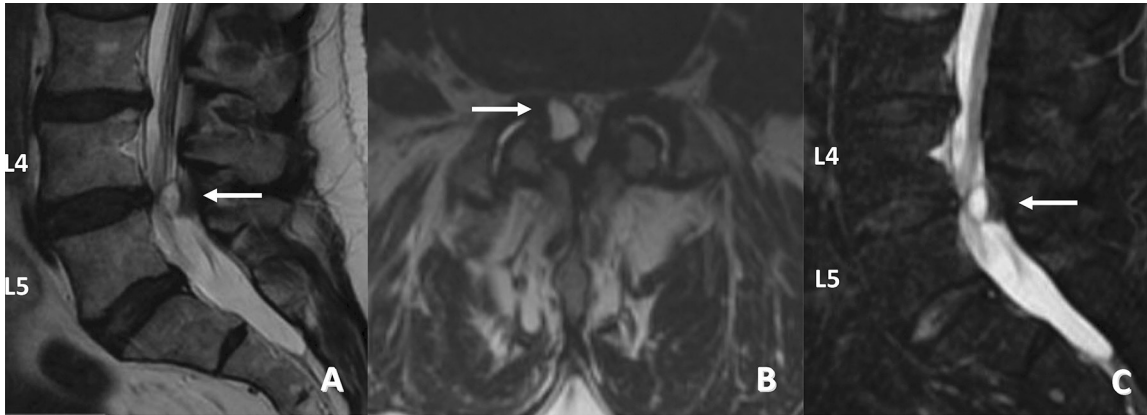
A) T1 sagittal computed tomographic (CT) image demonstrating a synovial cyst causing significant crowding at the L4-L5 vertebral level. B) T2 axial cut demonstrating severe central canal stenosis. C) T2 sagittal CT image.
